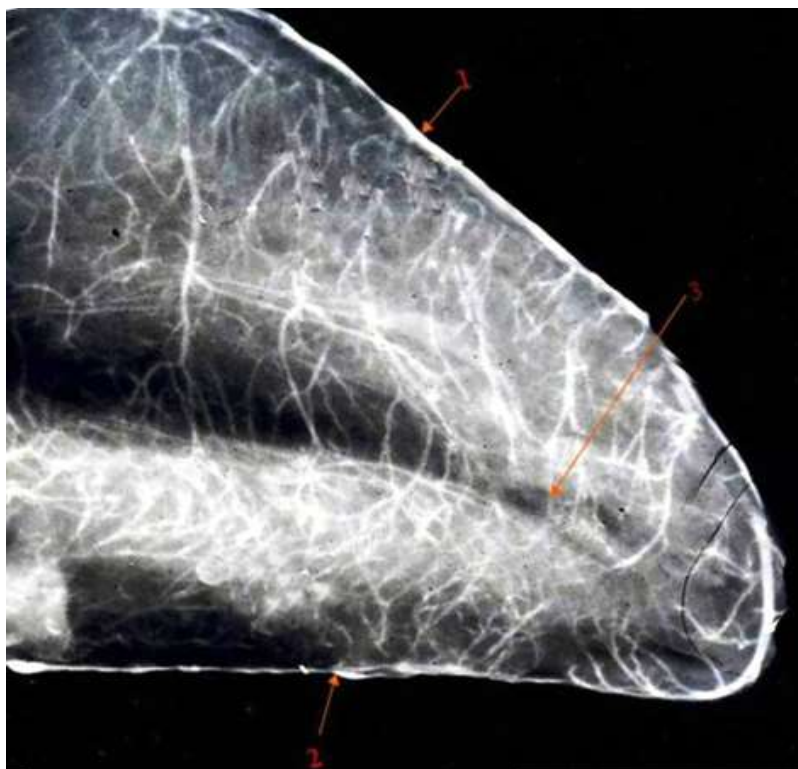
X-ray of isolated interventricular septum (1- Anterior interventricular artery, 2 - Posterior interventricular artery, 3 - Anastomotic vessels), Anterior septal arteries supplying ventral two-third of the septum and posterior septal arteries supplying dorsal one-third of the septum
